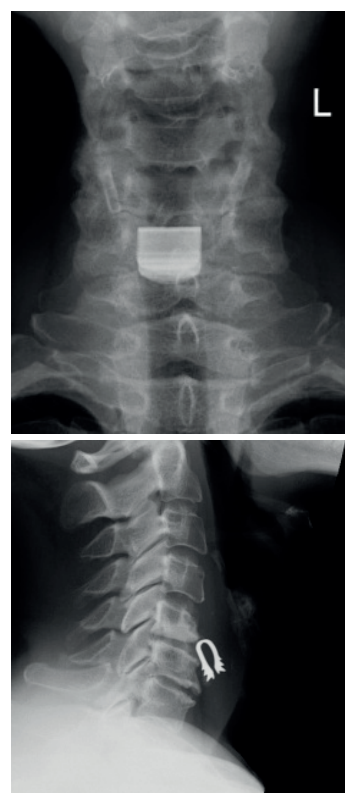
Case #5 with anterior dislocation of the C5/C6 intervertebral disc prosthesis. First figure presents lateral cervical spine X-ray along with an anteroposterior view on the right (the patient presented with cervical pain of 6 in the Numeric Rating Scale; this implant was removed and the space was refilled with biodegradable material)
